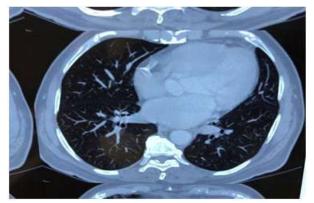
Follow-up HRCT thorax showing lung opacities and reduction in size of the nodes
